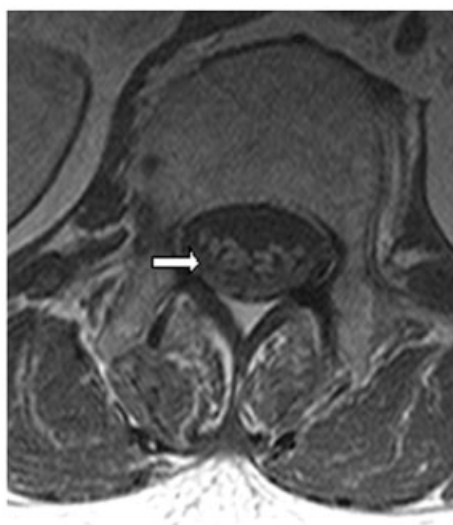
A 67-year-old woman with presumed acute myelopathy and markedly elevated cerebrospinal (CSF) protein. (A) T2-weighted sagittal magnetic resonance imaging is normal; (B) T1-weighted, gadolinium-enhanced axial section through the cauda equina with gadolinium showed enhancing nerve roots. Nerve conduction studies confirmed acute inflammatory demyelinating polyneuropathy.
